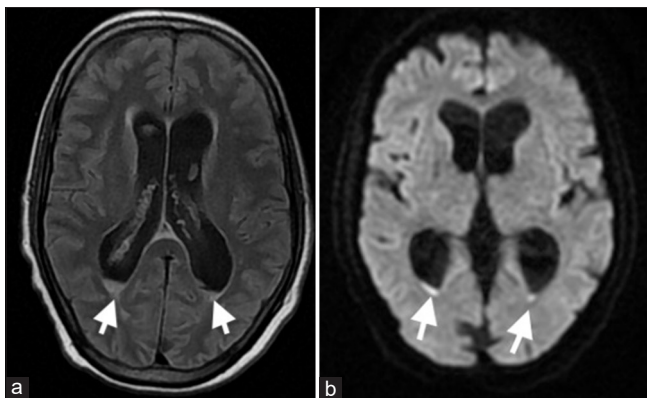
A 66-year-old man with chronic obstructive pulmonary disease who presented with altered mentation. (a) Brain magnetic resonance image T2-weighted fluid-attenuated inversion recovery shows hyperintense dependent signal within the occipital horns of the bilateral lateral ventricles (arrows). (b) Diffusion restriction in the corresponding regions (arrows).
